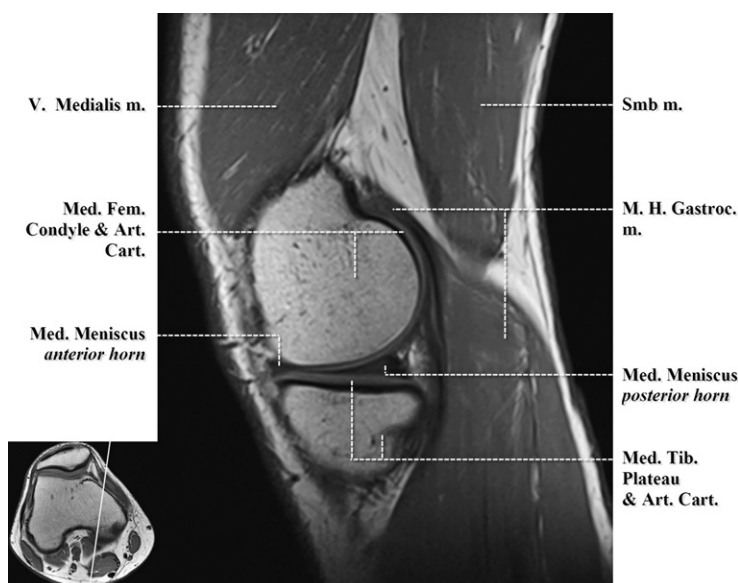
Sagittal T1-weighted image. Medial aspect of the knee through posterior horn of the medial meniscus. Art. Cart., articular cartilage; m., muscle; Med., medial; Med. Fem., medial femoral; Med. Tib., medial tibial; M.H. Gastroc., medial head gastrocnemius; Smb, semimembranosus; V., vastus.
